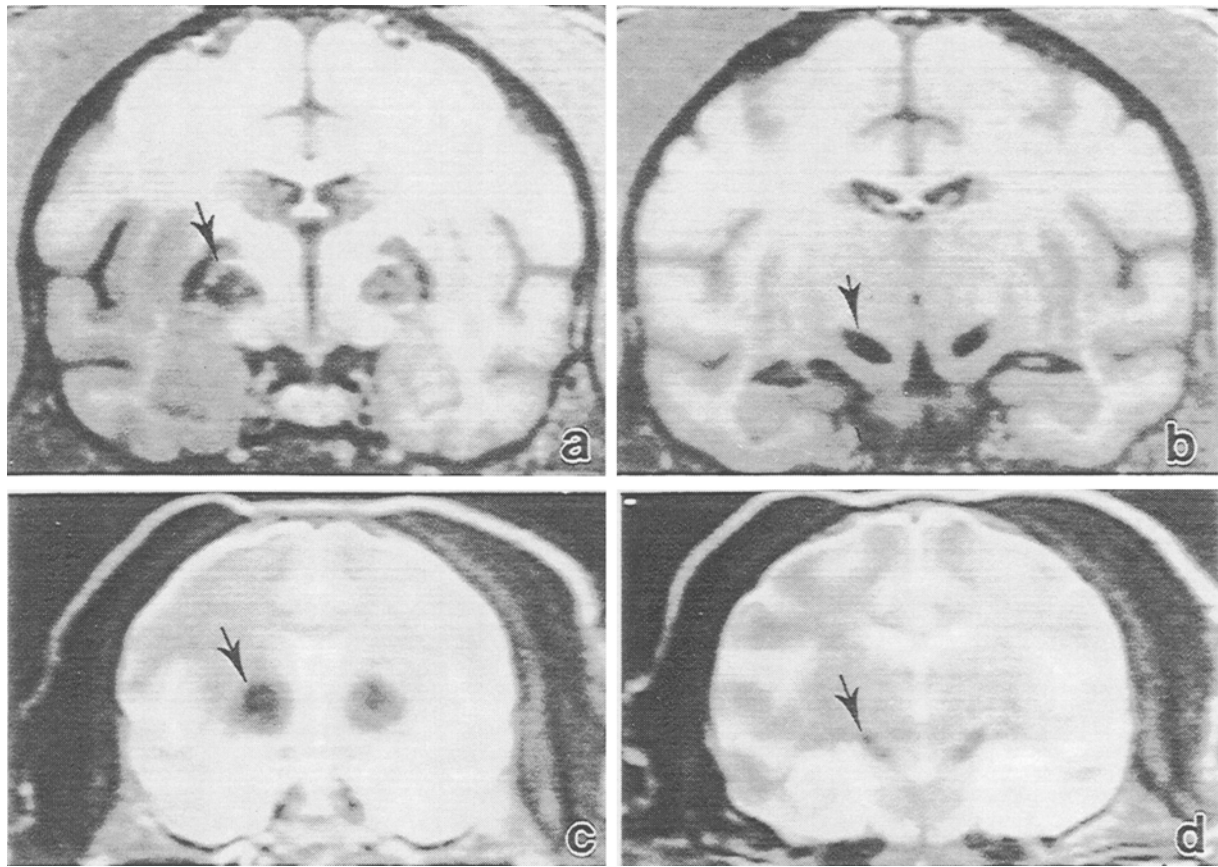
Magnetic resonance images of four coronal planes, [T-1, Tr=2000 msec, TE=20 msec. (a) and (b)] and T-2 dependent (c) and (d) showed reduced signal (black shadows, arrows) in the globus pallidus (a and c) and substantia nigra (b and d).
